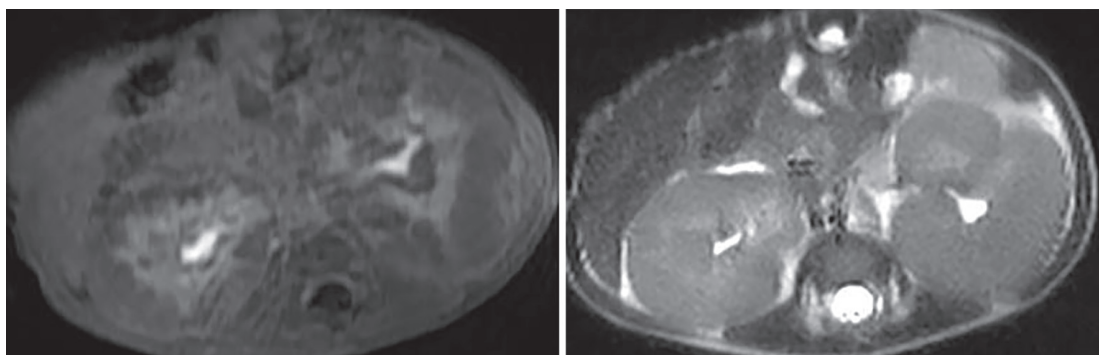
T1 and T2 weighted MRI images show complete replacement of renal parenchymas with thick rind of hypointense masses with no obvious enhancement compatible with diffuse nephroblastomatosis.
